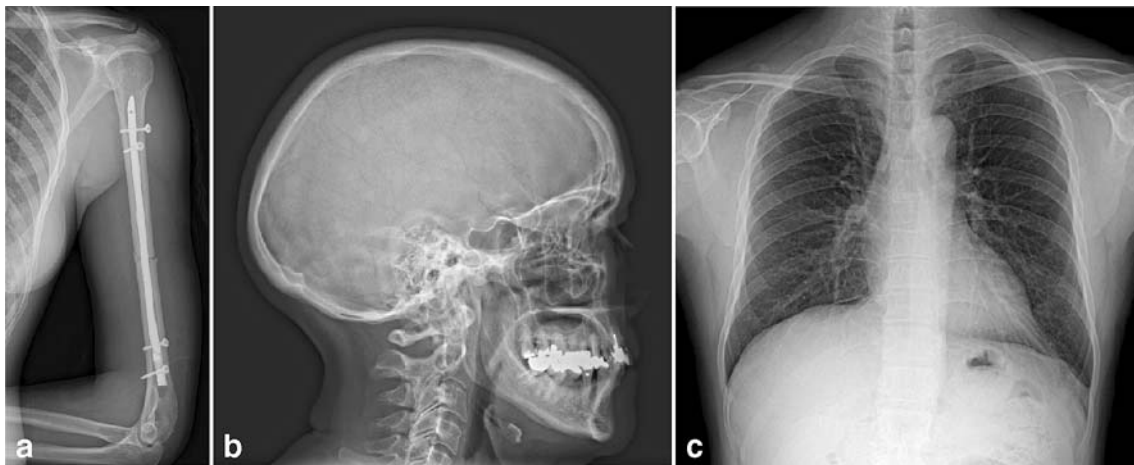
Image examples of a an upper arm, b a skull and c a thorax a.p. acquired with an AXIOM Aristos MX system for general radiography (Siemens)
